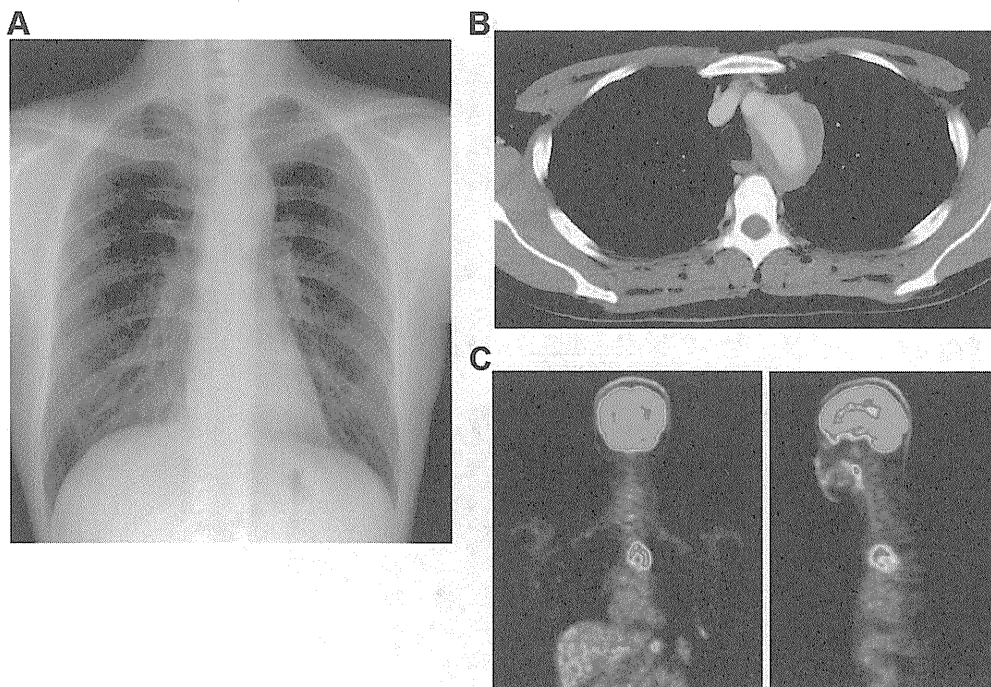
Before the corticosteroid therapy, the chest radiograph (A) showed an abnormal protrusion of the aortic arch, contrast medium-enhanced CT (B) of the chest revealed a periaortic mass in the mediastinum and ¹⁸F-FDG-PET (C) showed increased tracer uptake at the aortic arch.
